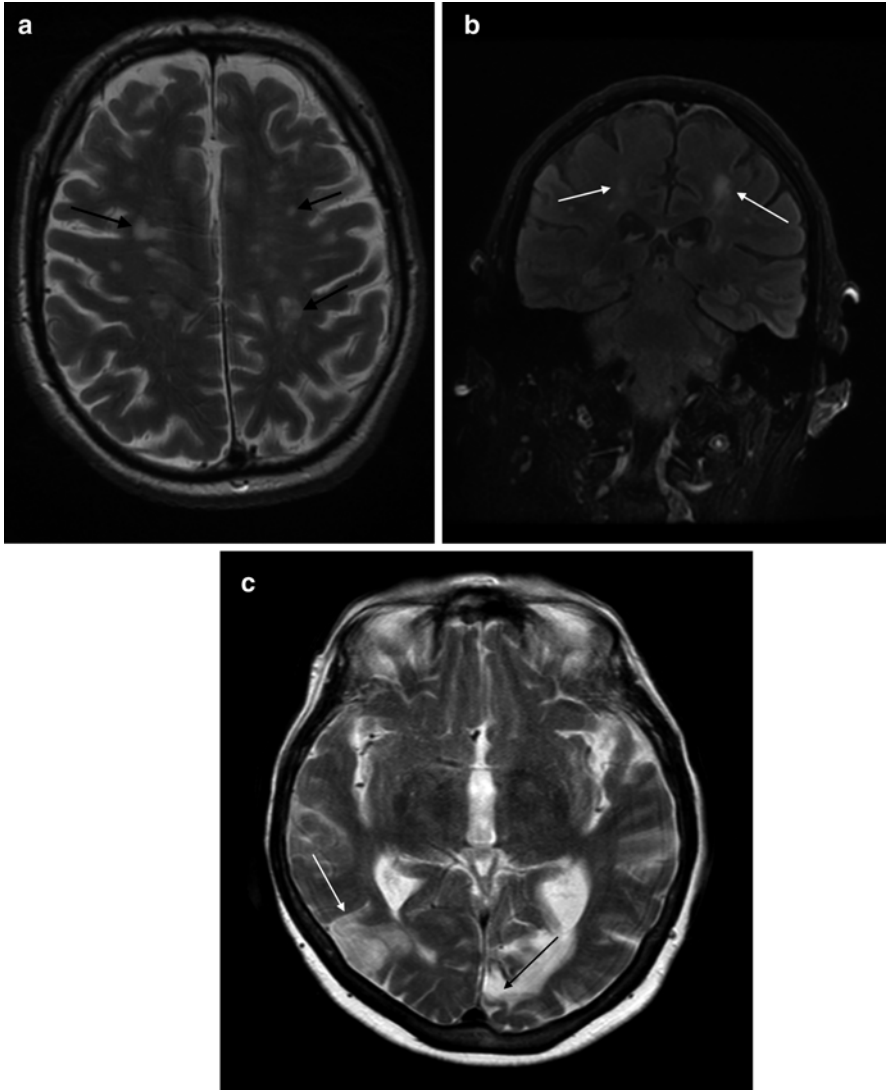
Cerebral borderzone ischaemia. (a and b) T2 axial and T2 FLAIR coronal images showing ischaemic lesions (*arrows*) along the deep ACA/MCA borderzone. (c) T2 axial image showing right posterior MCA borderzone cortical infarction (*white arrow*) and an old left occipital lobe infarct (*black arrow*)
